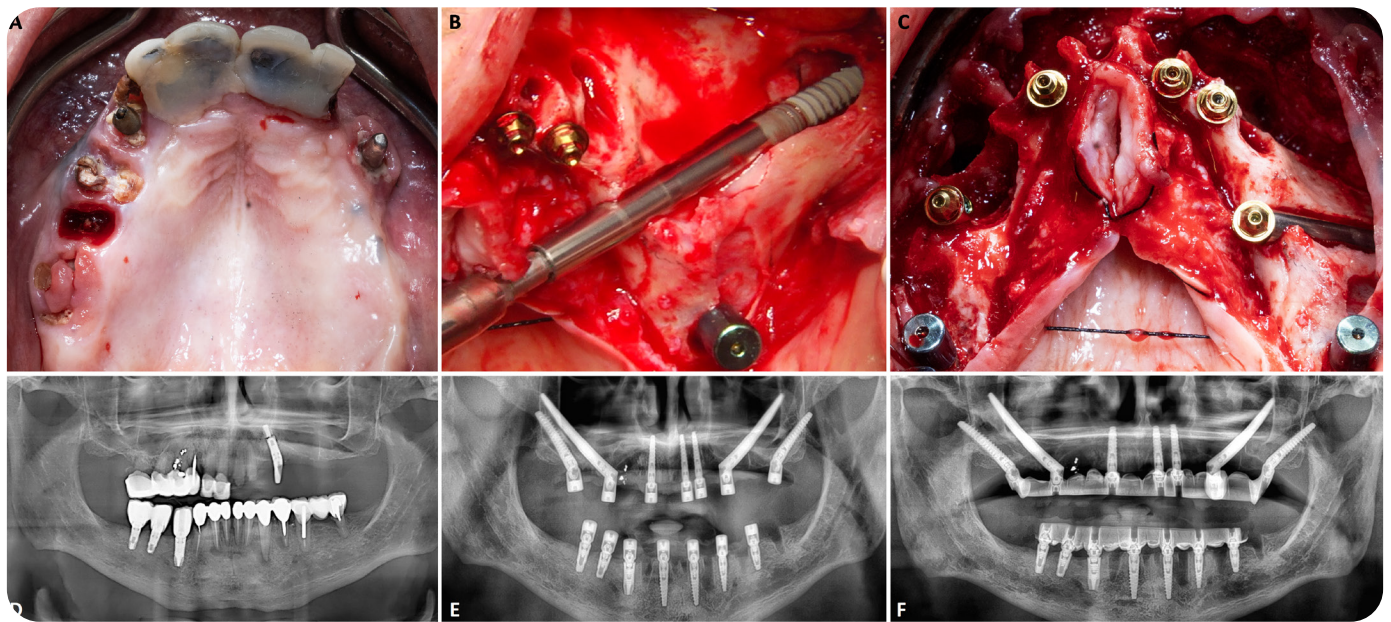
(A) Preoperative and (BC) intraoperative surgical views. (D) Preoperative and (EF) postoperative panoramic radiographs.
